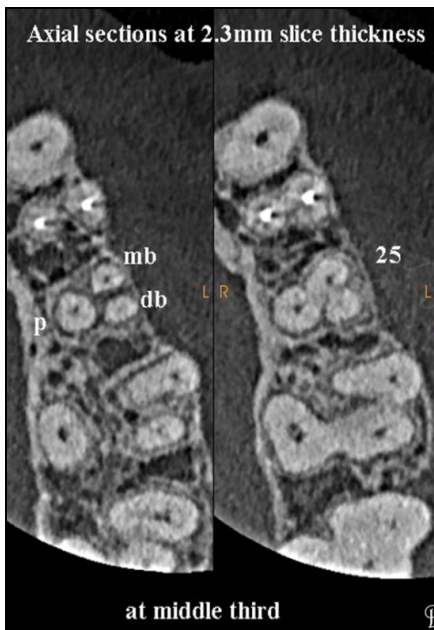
CBCT reveals 3 canals – mesio-buccal, distobuccal & palatal
